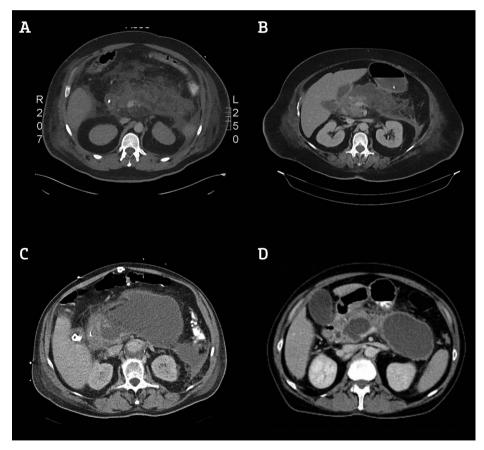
(A) CT: not encapsulated (0%), (B) CT: moderately encapsulated (<50%). (C) CT: largely encapsulated (50-99%). (D) CT: fully encapsulated /walled-off necrosis (100%).
